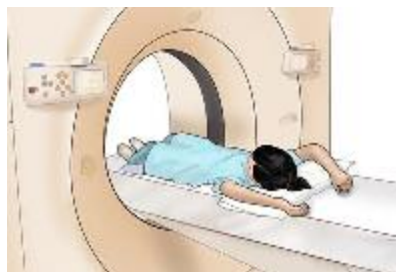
CT scan Procedure
